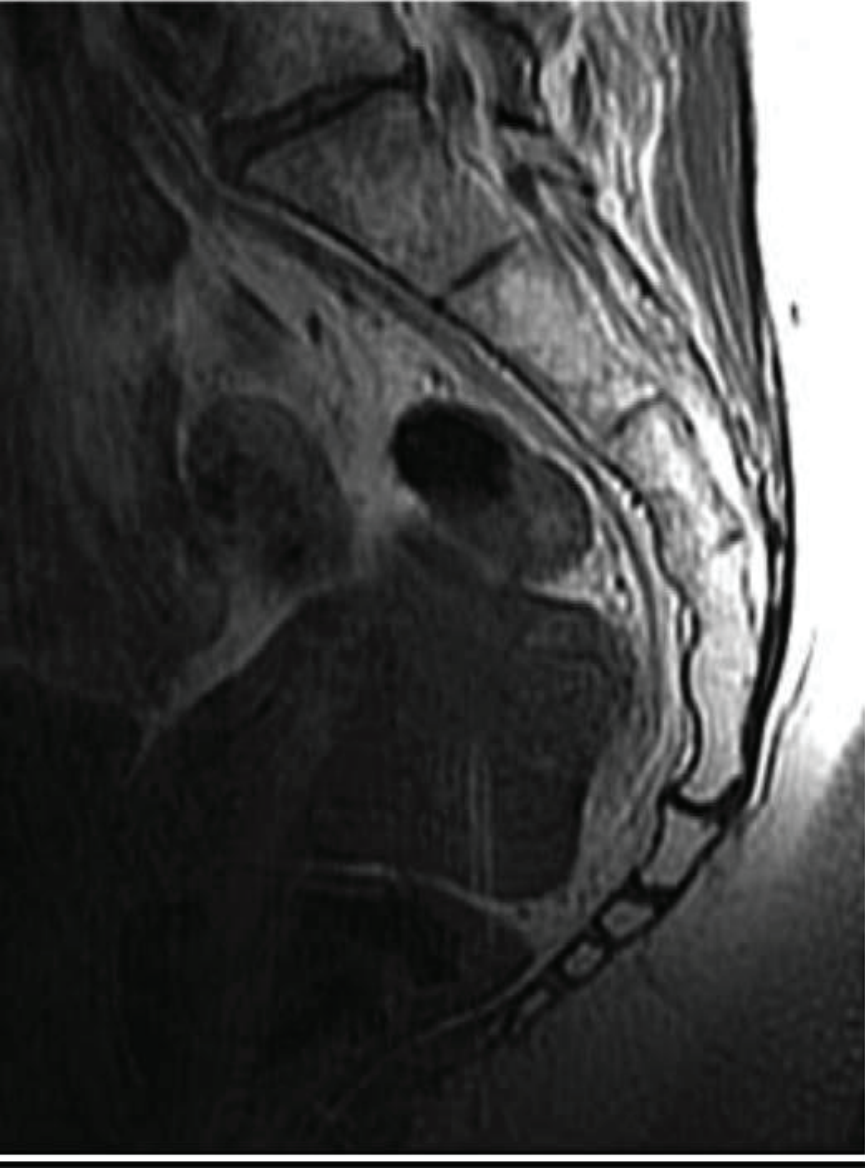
MRI. Normal coccyx
